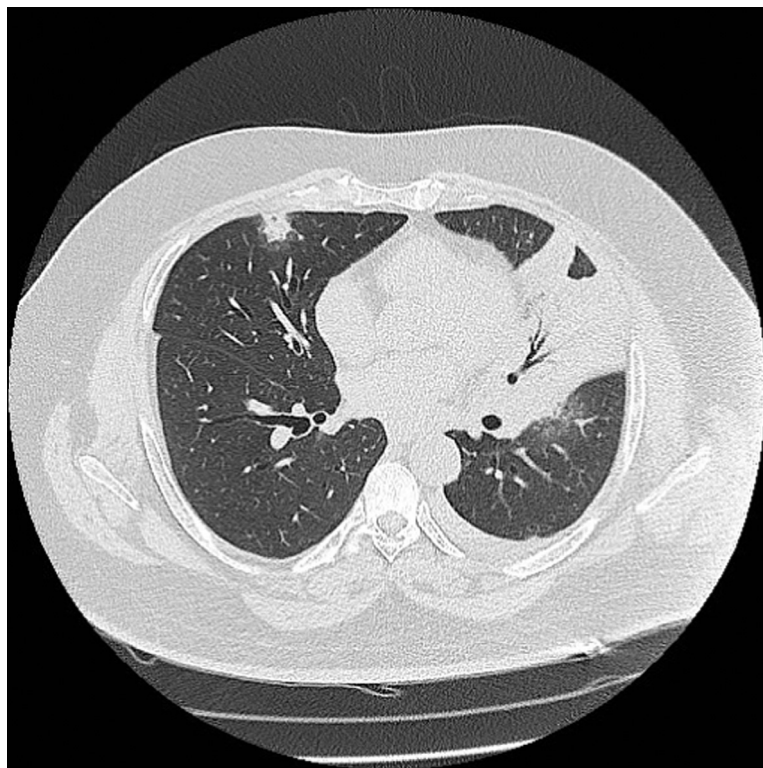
A case of MERS-CoV; Axial CT in pulmonary window 2 days after admission showing left pulmonary consolidation with smaller one (not seen in X-ray) within the right middle lobe.
